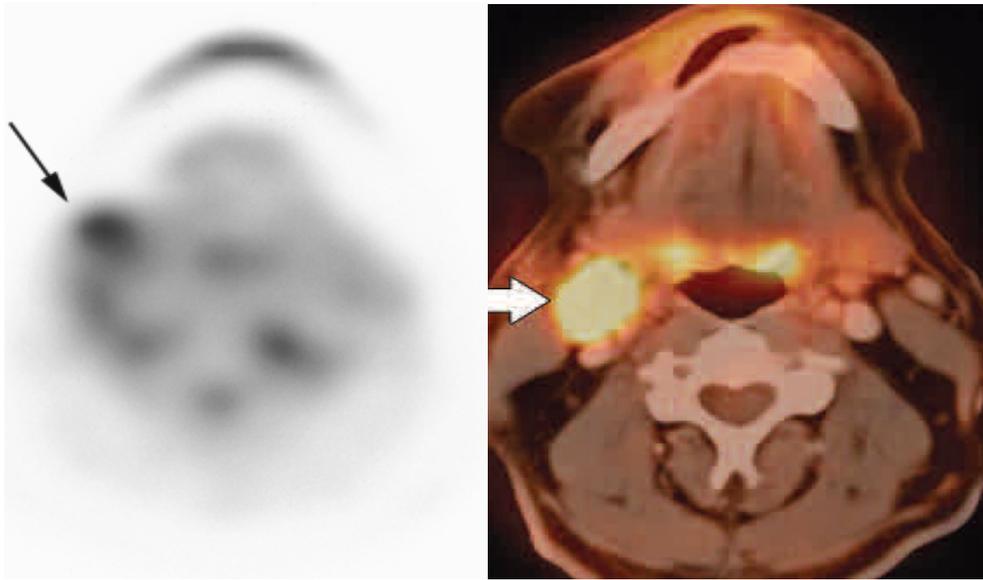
Tomogram from PET with poor anatomical resolution and tomogram with PET-CT-a combining morphological information and information about increased metabolism: metastatic lymph node of pyriform sinus cancer on the right side of the neck (arrow)(8).
